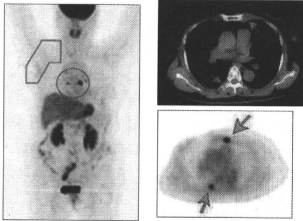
70歳、女性。乳がんの乳房切除術後。患側の鎖骨上窩へ腋窩(赤線)に対する放射線治療を依頼されたが、FDG-PETにより多発骨転移(青曲線、矢印)が指摘され治療方針の変更となる。
